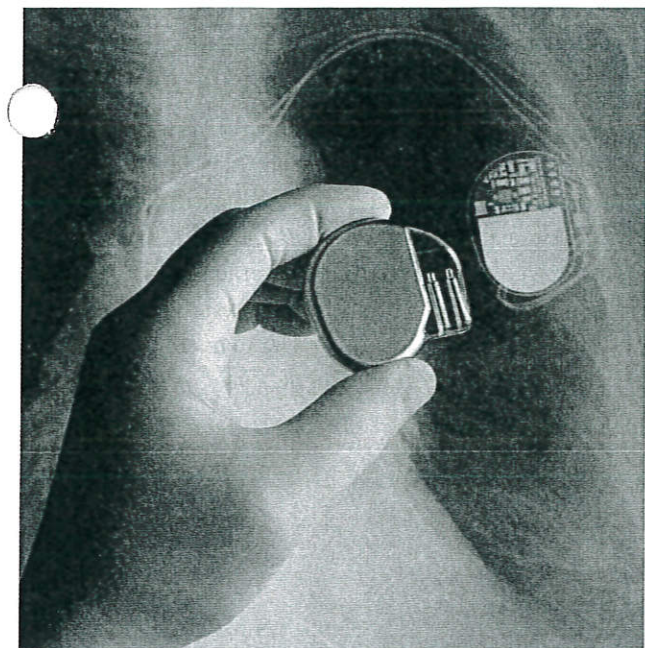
A surgeon holds a pacemaker next to an X-ray of a pacemaker implanted in a patient's chest.
